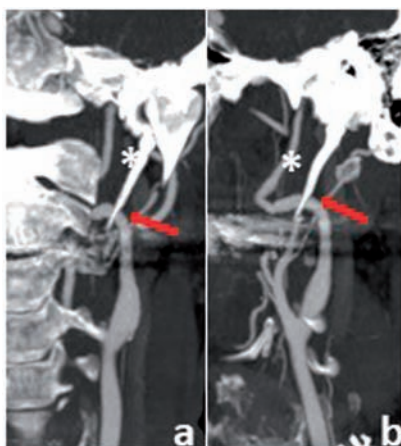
CT-angiography (a: coronal view; b: sagittal view) shows an elongated styloid process (ESP) (red arrow) in close proximity to the left internal carotid artery (ICA). Left ICA dissection (*) is demonstrated distal to elongated styloid process abutting the vessel.
